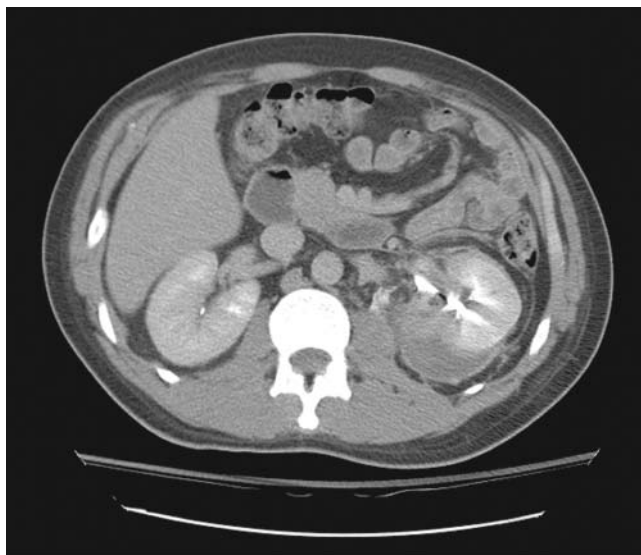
Computed tomographic scan showing an infected urinoma in a patient with left grade IV injury who presented 7 days after injury with fever and sepsis and subsequently underwent ureteral stenting. The urinoma was drained percutaneously.
